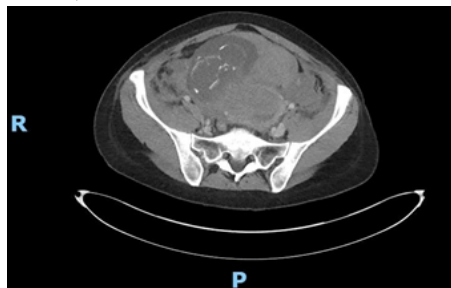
CT Scan Of Pelvis
